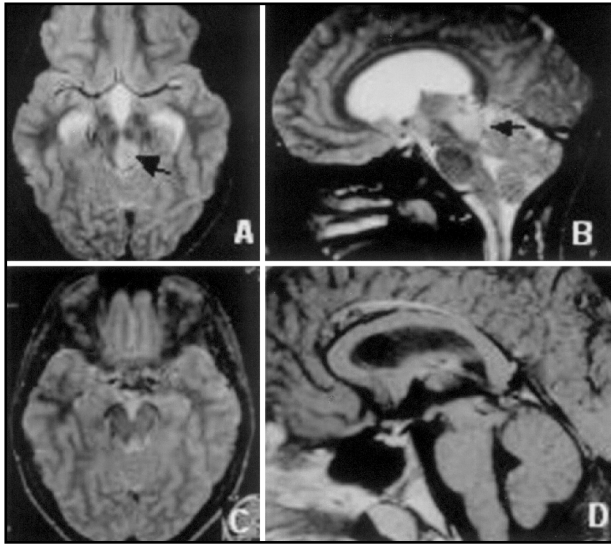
Preoperative T2-weighted MRI (A, B) tumor (black arrows). Postoperative MRI (C, D) 10 1/2 years after surgery showing total removal.
